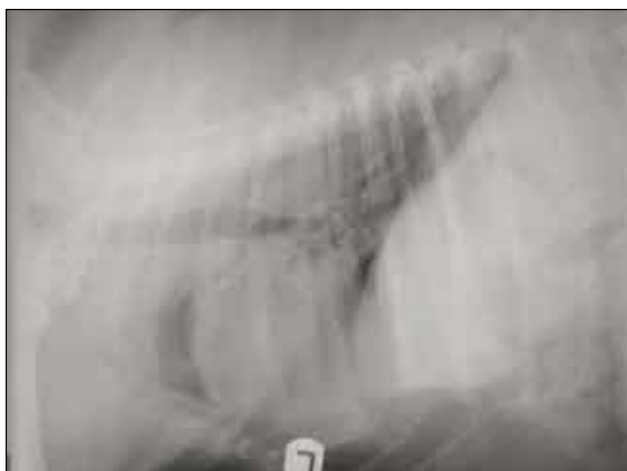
Expiratory left lateral recumbent thoracic radiograph of an obese 13-year-old Labrador Retriever.
